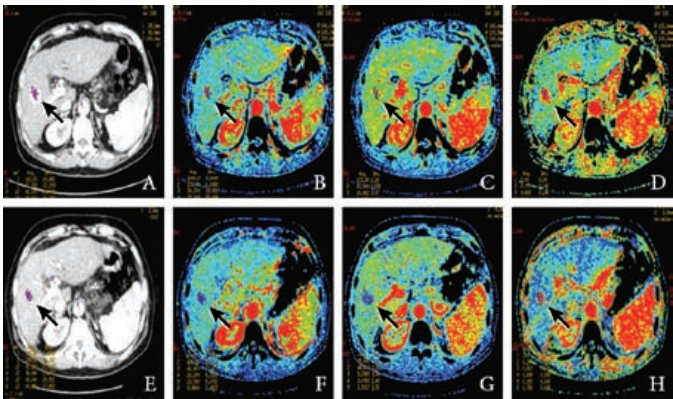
Images of enhanced CT and CT perfusion of the controls and HCC foci. A-D: CT enhancement and CT perfusion performed in the controls. E-H: CT enhancement and CT perfusion performed in HCC foci. Black arrows show the delimitation of HCC foci in the hepatic right-lobe.
